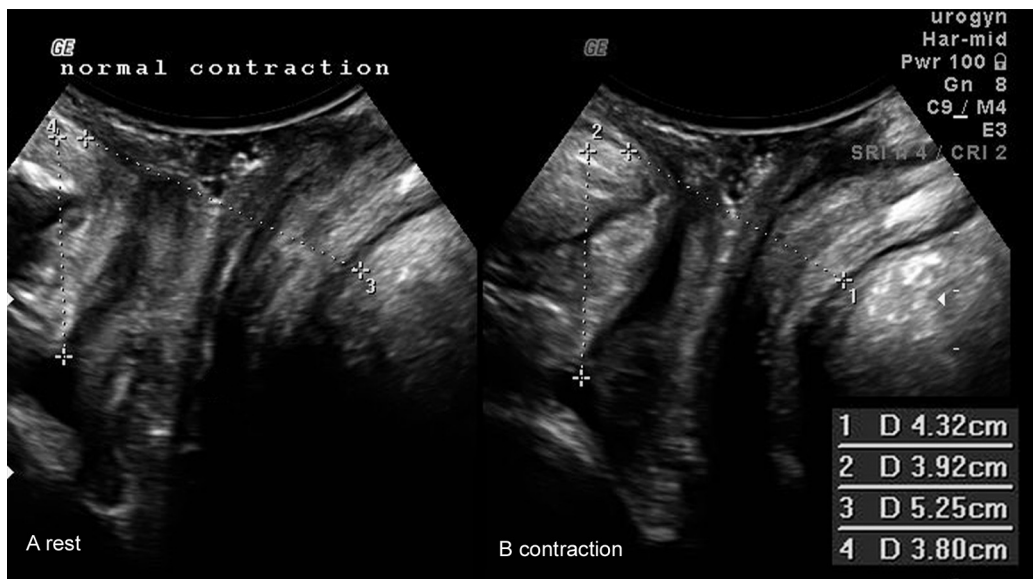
Levator contraction on pelvic floor ultrasound, A at rest and B in contraction. Measurements for contraction are taken at the level of the bladderneck (measurement 2 and 4) and at the level of minimal hiatal dimension (measurement 1 and 3), using the inferior margin of the pubic bone as reference point.
